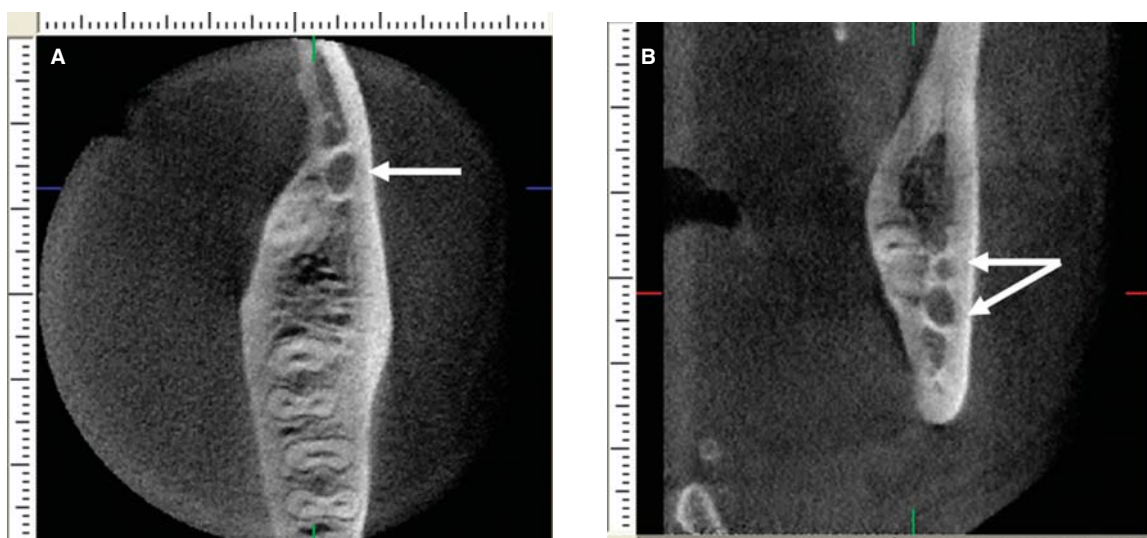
The cone beam CT images reveal a bifid mandibular canal in the retromolar area, arising from the principal alveolar canal. Assial (A) and coronal (B) plane slice.
